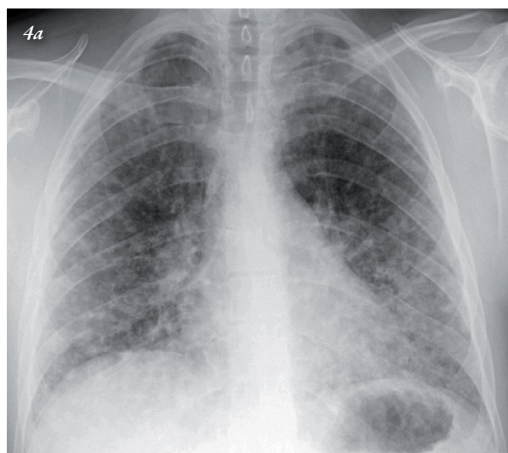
Chest x-ray of case 2.
